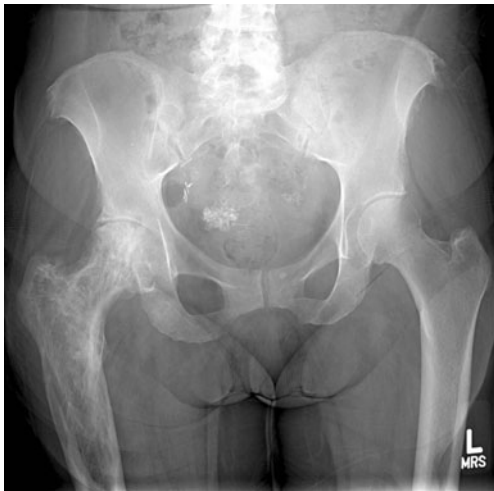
Frontal pelvis radiograph
